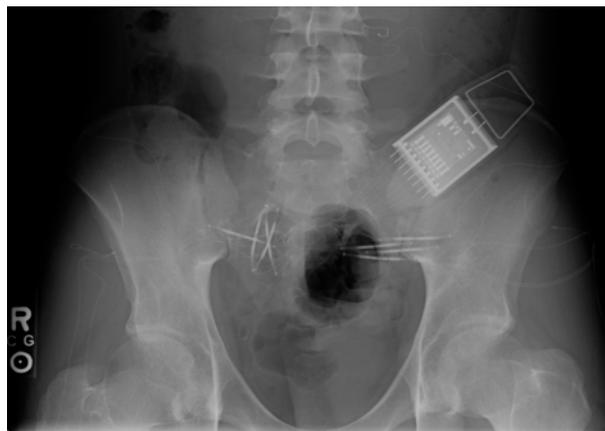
X-ray of 8-IRS and electrode connections.
